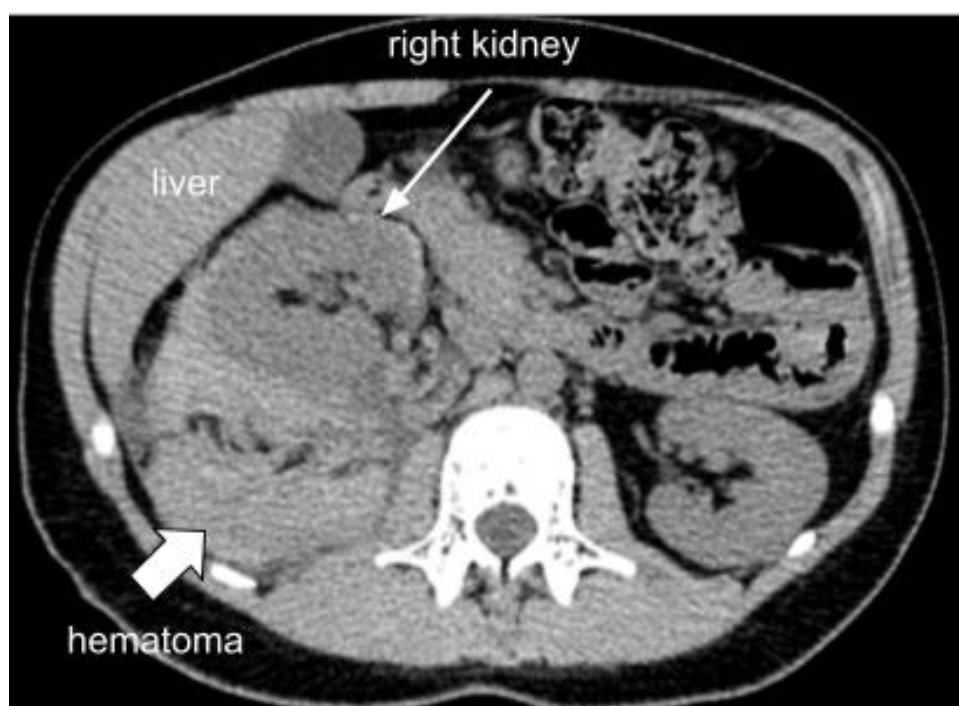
Axial computed tomography scan demonstrating perirenal hematoma determining anterior displacement of the kidney.
